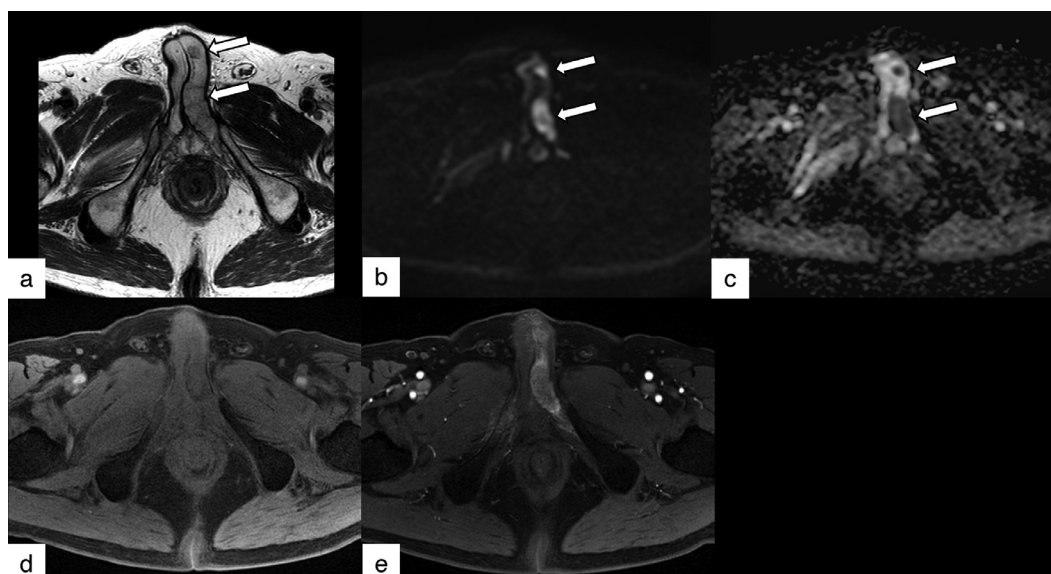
(A) Axial T2-weighted image; (B, C) Axial diffusion-weighted image ($b = 1000 \text{ s/mm}^2$) and apparent diffusion coefficient map; (D, E) Axial pre and postenhanced T1-weighted fat-saturated image. Axial T2-weighted image showing 2 nodules with low intensity in the left corpus spongiosum (A). The nodules show high intensity on diffusion-weighted images with a low apparent diffusion coefficient (B, C). Contrast-enhanced T1-weighted fat-saturated image shows enhancement of the nodules (D, E).
